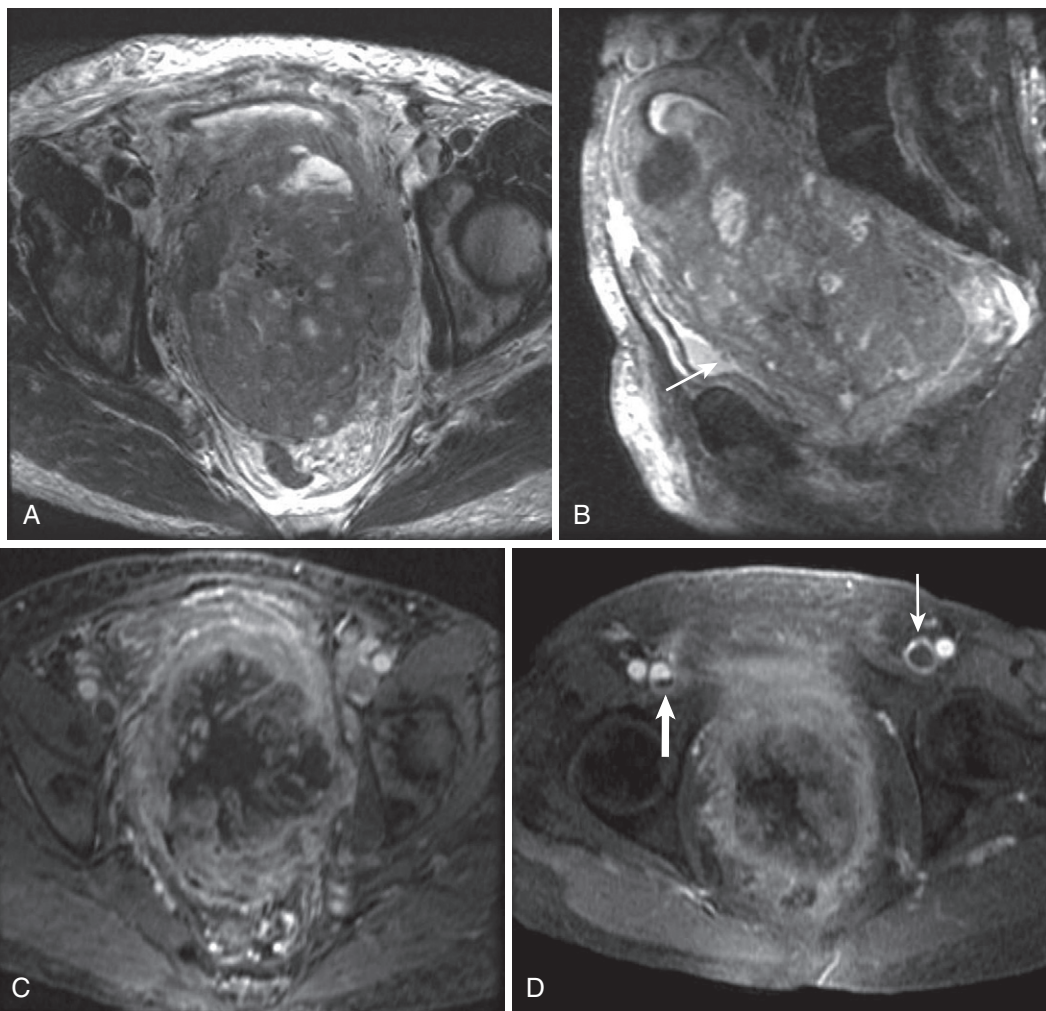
Cervical carcinoma with local invasion of rectum and/or bladder. A large, heterogeneous mass displaces the bladder anteriorly on the axial T2-weighted image (A), virtually replaces the entire uterus on the sagittal T2-weighted image (B), and invades the bladder, which features endoluminal irregularity indicating transmural extension (arrow in B). C, Gadolinium enhancement shows central necrosis. D, The delayed image shows near-occlusive (*thin arrow*) and nonocclusive (*thick arrow*) thrombus in the common femoral veins.
